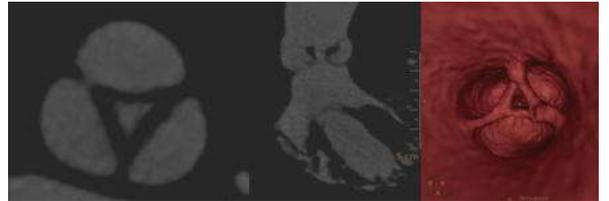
(A-C). CT Aortic angiogram (A, B) and virtual angiography (C) images reveal thickened tricuspid aortic valve leaflets causing mild aortic stenosis.
